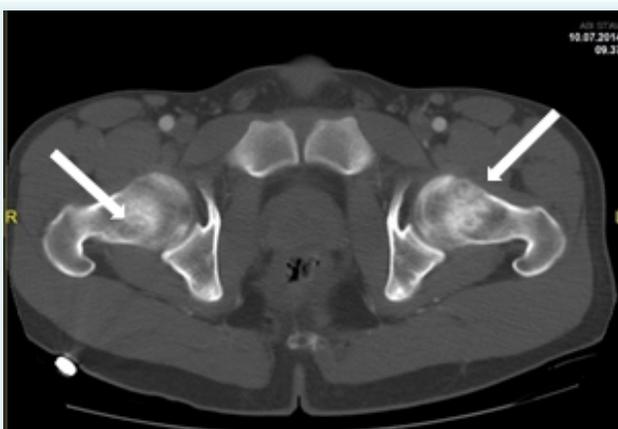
Pelvic CT scan showing osteopenia of both hip bones, greater on the left side
